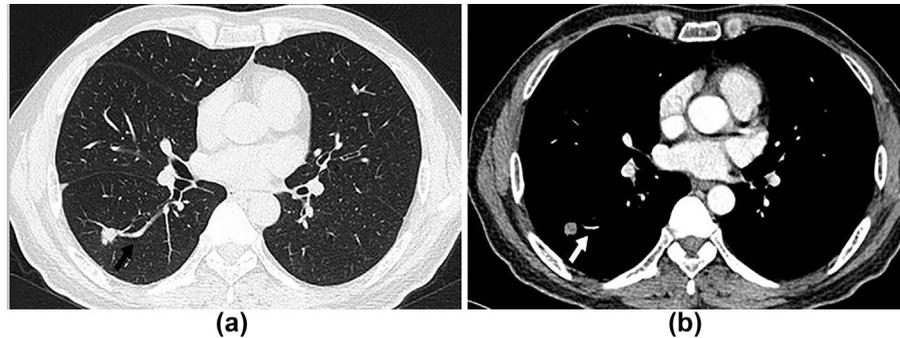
CT images of a 48-year-old man with EGFR exon 19 mutation lung adenocarcinoma. (a) CT lung window image shows that a thickened pulmonary vessel is pulled and then cut off by the lesion (arrow). (b) Enhanced CT image shows thickened enhanced blood vessels (arrow).
